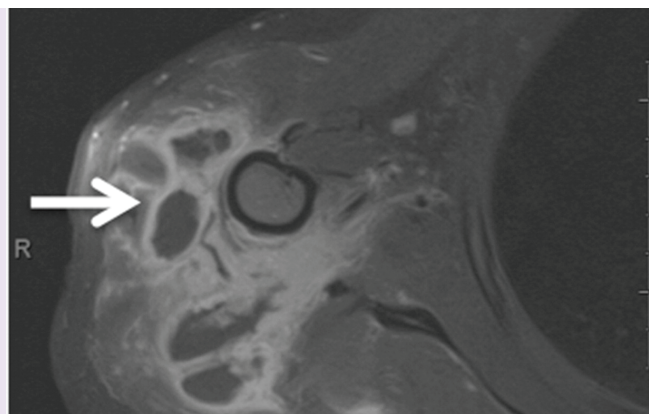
Fat-suppressed contrast-enhanced T1-weighted image of the deltoid region showing multiple thick-walled abscess cavities (arrow) following deltoid augmentation with fat transfer.
